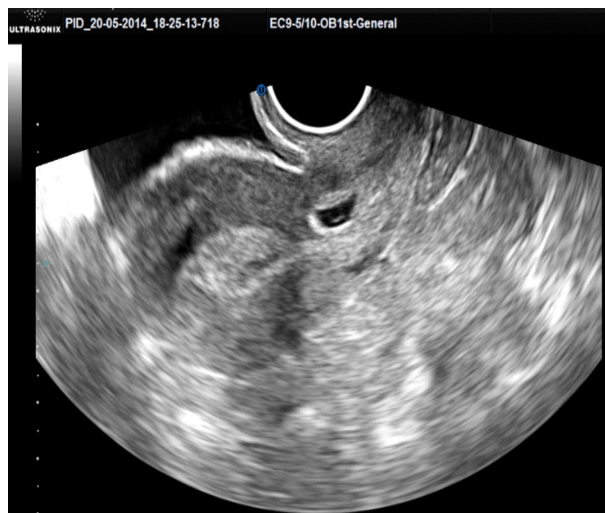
Transvaginal ultrasound images of an ectopic cervical pregnancy: empty uterine cavity, gestational sac within the cervical canal, below the level of the cervical internal os, with trophoblastic ring and embryonic echo without cardiac activity.
